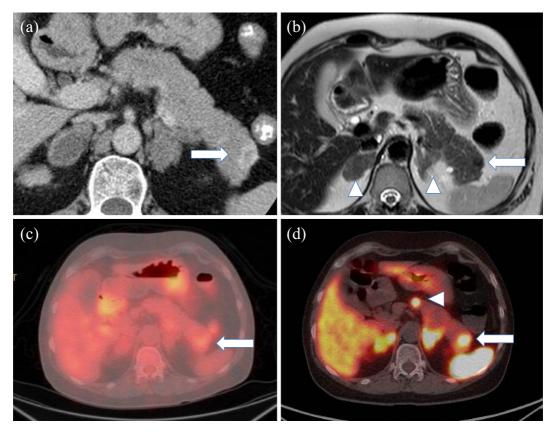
(a) Abdominal dynamic CT demonstrating a gradually ring-enhancing tumor in the distal region of the pancreas. (b) T2-weighted MRI demonstrating a low-signal-intensity pancreatic tumor (shown with an arrow) and enlarged adrenal glands (shown with arrow heads). (c) ¹⁸F-fluorodeoxyglucose positron emission tomography/CT (FDG-PET/CT) demonstrating a significant tumoral uptake. (d) ⁶⁸Ga-labeled 1,4,7,10-tetraazacyclododecane-*N*,*N*',*N*",*N*"-tetraacetic acid-dPhe¹-Tyr³-octreotide PET/CT (DOTATOC-PET/CT) demonstrating significant uptake by the tumor in the pancreatic distal region and a separate tumor in the pancreatic body (shown with an arrow head).
